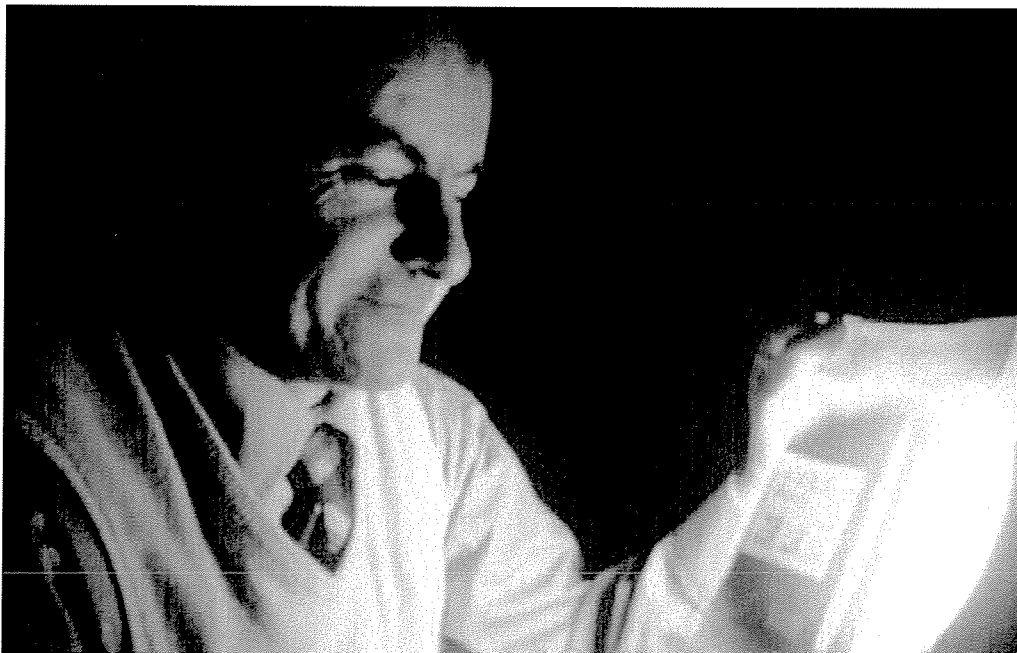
Interpretation of a radiograph with a high-intensity illuminator. (Courtesy Charles J. Hellier.)
